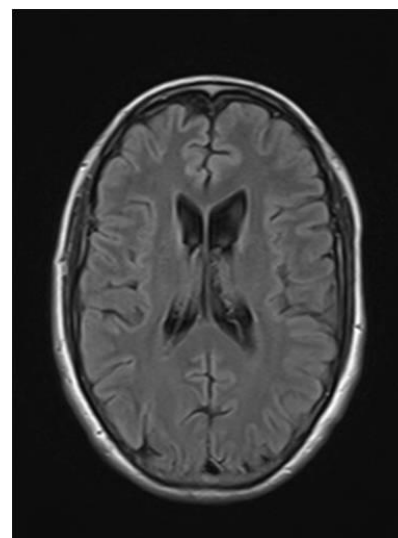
Atrophy of the head of caudate nuclei; and cerebral atrophy in axial brain MRI
